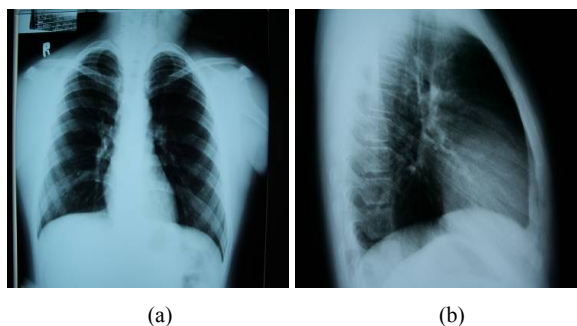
Chest x-ray (a) and (b) showed hyperaerated lung
